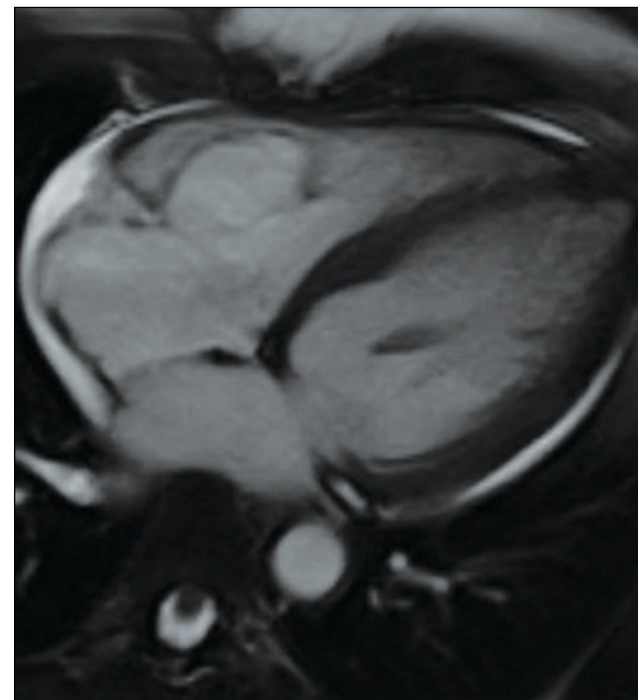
Cardiac MRI – four-chamber view.
